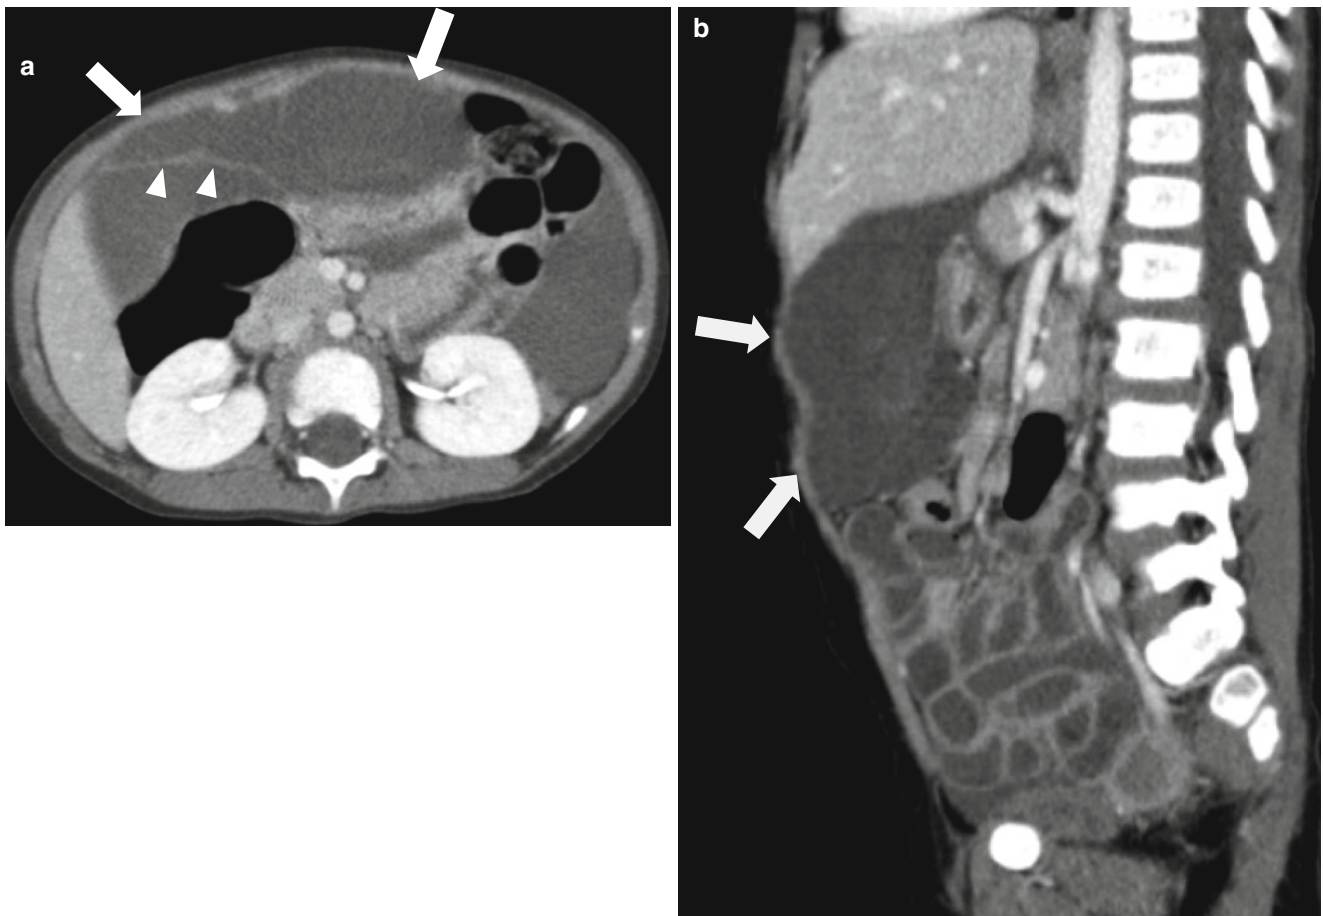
Cystic lymphangioma in the omentum. (a, b) Axial and sagittal contrast-enhanced CT of 2-year-old boy show a huge cystic mass arising from lesser omentum (*arrows*). Fine-enhancing septa are seen within the cystic mass (*a*, *arrowheads*)
